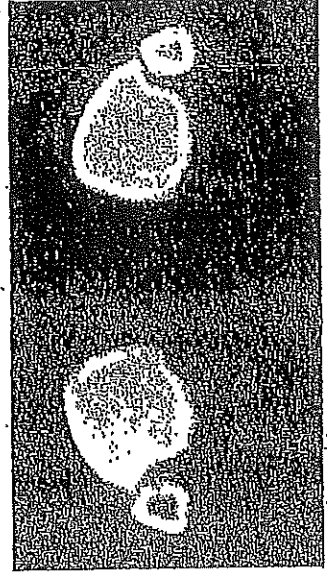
CT scan of the bilateral ankles with DTFJ disruption. The TCS can be measured on the axial cuts as the distance between the posterior fibula incisure and the medial cortex of the tibia. The TCS will be increased in the side with the DTFJ disruption versus the contralateral extremity.
